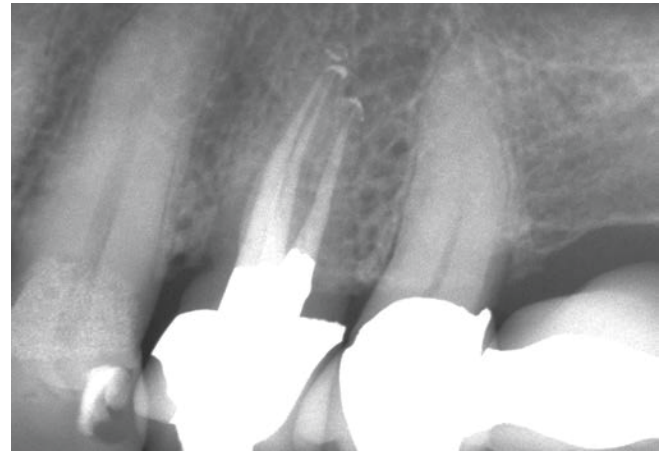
This radiograph demonstrates endodontic treatment of a maxillary 1st bicuspid with 3 roots and related systems.
